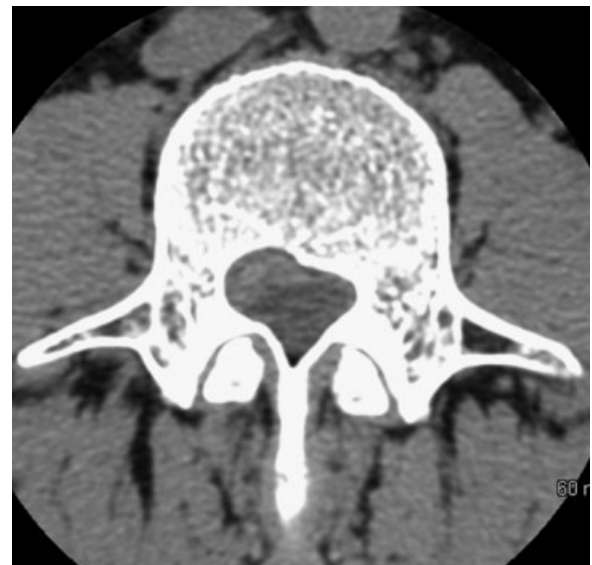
CT scan reveals the bone erosion and the enlargement of L4 lateral recess. CT, computed tomography.
